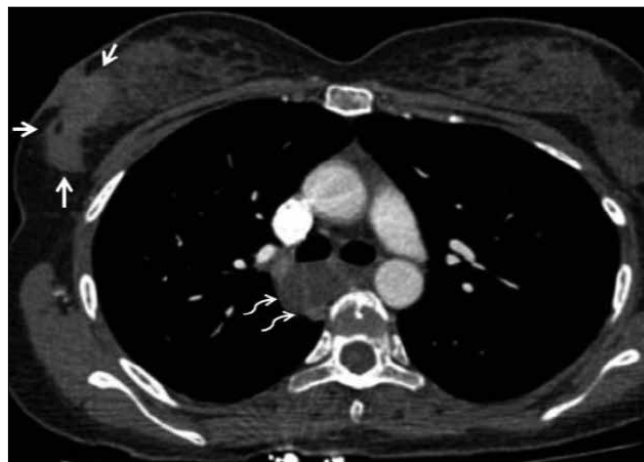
A solid mass (white arrows) of the right breast involving the upper outer quadrant, which is expanding to the skin and with lobulated contour and a mass lesion (curved arrows) of the mediastinum in retrocarinal localization, with lower density on the axial thorax computed tomography fraction with contrast agent
